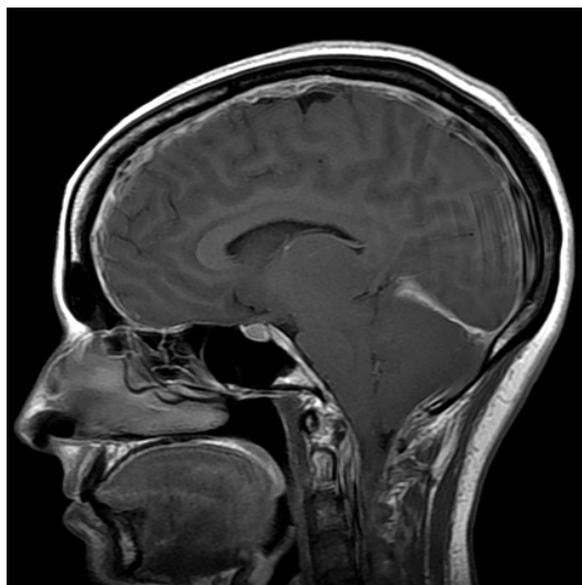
Gadolinium-enhanced T1 weighted sagittal MRI image demonstrating brain sagging and posterior fossa crowding with diffuse pachymeningeal enhancement extending towards the cervical spine, being specially prominent and thick at the C2 level
